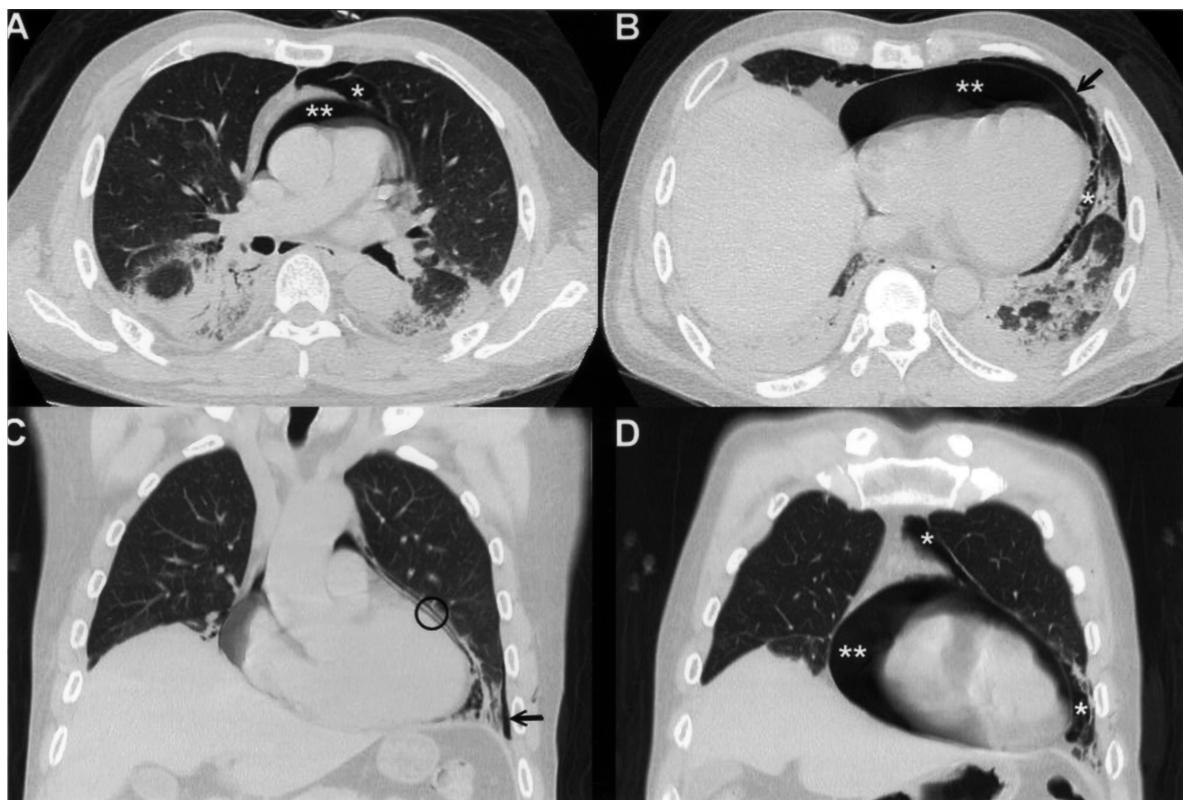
Lung window setting of the chest CT: Panels A and B are axial views and panels C and D are frontal views. The asterisk (*) denotes pneumomediastinum, which extends to the upper mediastinum and comprises a soft tissue web within it. The double-asterisk () denotes pneumopericardium, which is confined to the pericardial sac. The heart is surrounded by a broad band of air (halo sign) on panel D. The black arrows denote the mild left-side pneumothorax. The circular area (○) on panel C comprises both the visceral pleura and pericardium, as described in the legend of Fig. 2.
